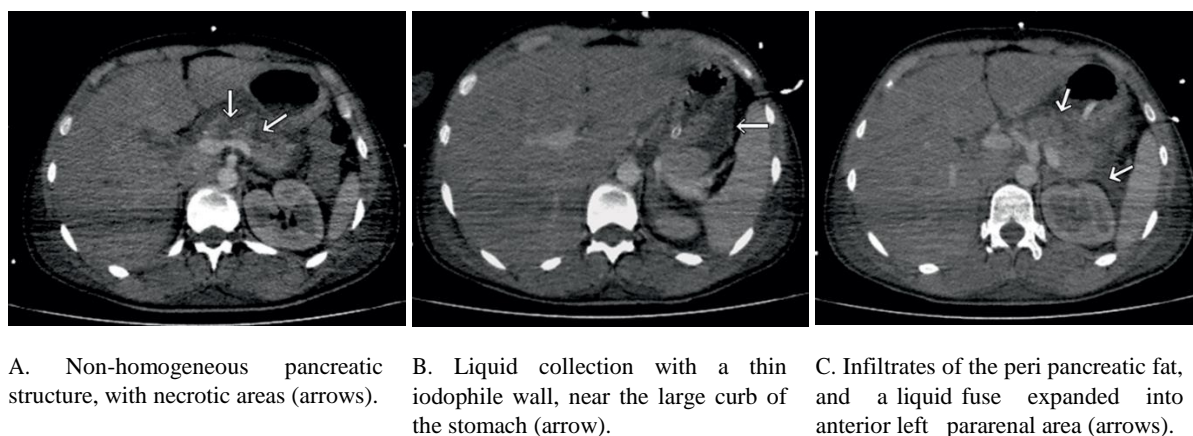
8. Contrast-enhanced CT scan shows evidence of necrotic pancreatitis.
